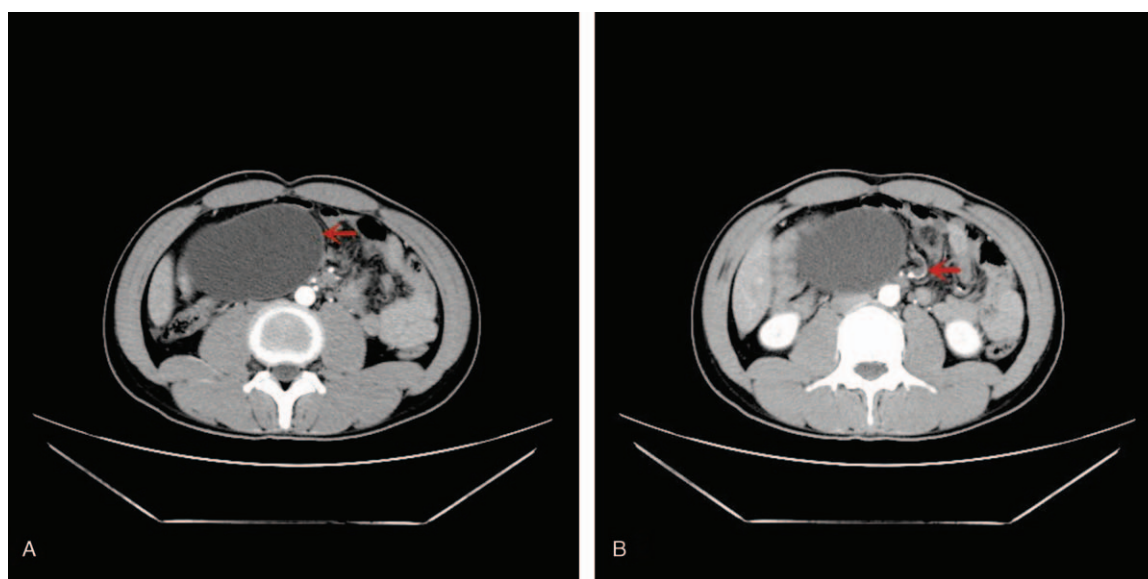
Features of the duplication on computed tomography scan. (A) A demonstration of a well-margined cyst mistaken initially as a distended bowel loop (arrow), which was definitely an intestinal duplication verified intraoperatively and retrospectively, full of hemorrhagic fluid. (B) A description of twisting of mesenteric vessels around each other at the base of the cyst (arrow), suggestive of the whirlpool sign.
